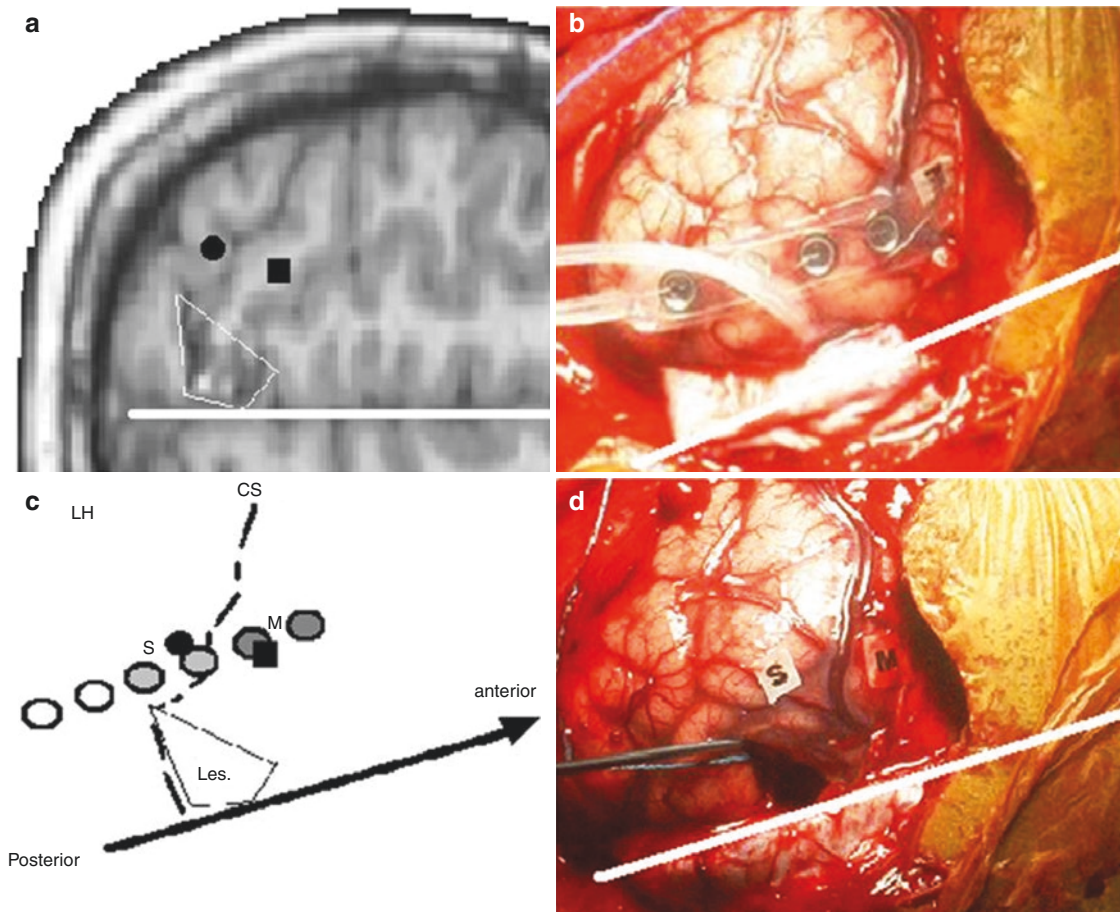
Intraoperative verification of MEG-derived estimates for primary somatosensory (S) and motor (M) cortex. (a): Axial view of patient's MRI. The MEG-derived estimates for sensory (black circle) and motor (black square) are projected close to the patient's lesion (cavernous angioma). (b): Intraoperative photograph showing the placement of a strip of electrodes for sensory and motor mapping. (c):
